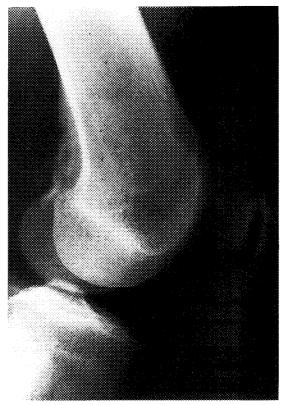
Periosteal desmoid. A 17-year-old boy was asymptomatic until he sprained his knee while playing football. A lateral radiograph shows a radiolucency on the posterior face of the distal metaphysis of the femur.
